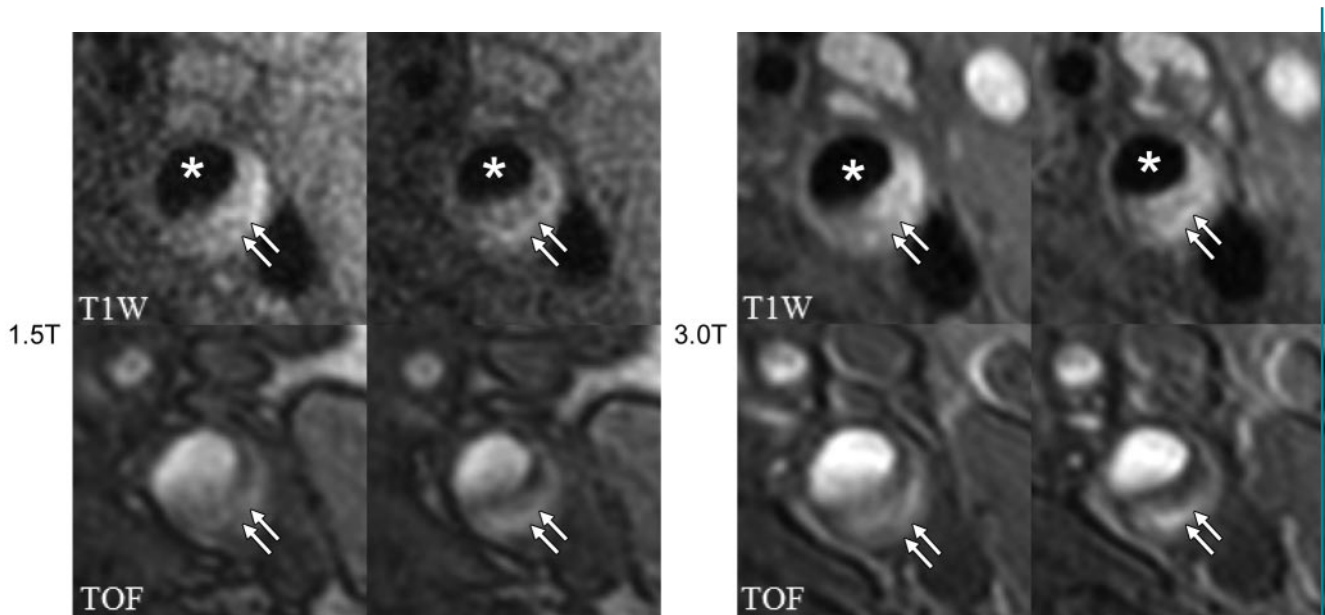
Comparison of advanced lesion in left internal carotid artery in 65-year-old man at 1.5 T (left) and 3.0 T (right). Intraplaque hemorrhage (arrows) is present in this lesion, identifiable by the hyperintense signal on T1-weighted (*T1W*) and TOF images at both field strengths. Of note, the image quality at 3.0 T is improved compared with that in matched locations at 1.5 T. * = Lumen of internal carotid artery.
